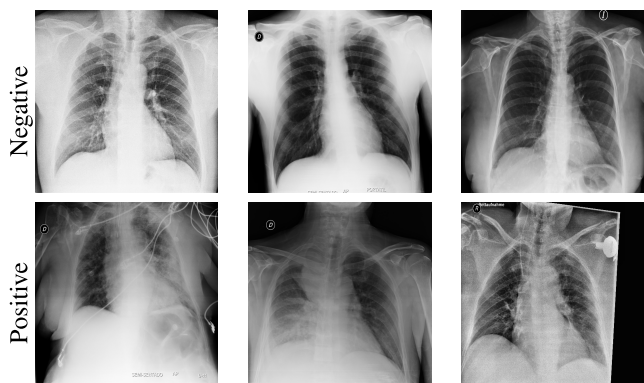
Chest X-ray samples from datasets in the reviewed papers. The top row shows COVID-19 negative samples and the bottom row shows positive ones.
